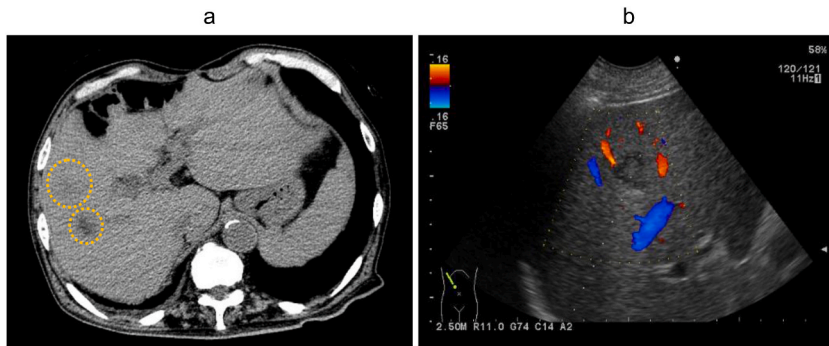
(a) Abdominal computed tomography revealed 2 hypodense lesions in the right liver lobe (yellow circles). (b) Doppler abdominal ultrasonography showed an echogenicity-mixed hypoechoic lesion without blood flow.
